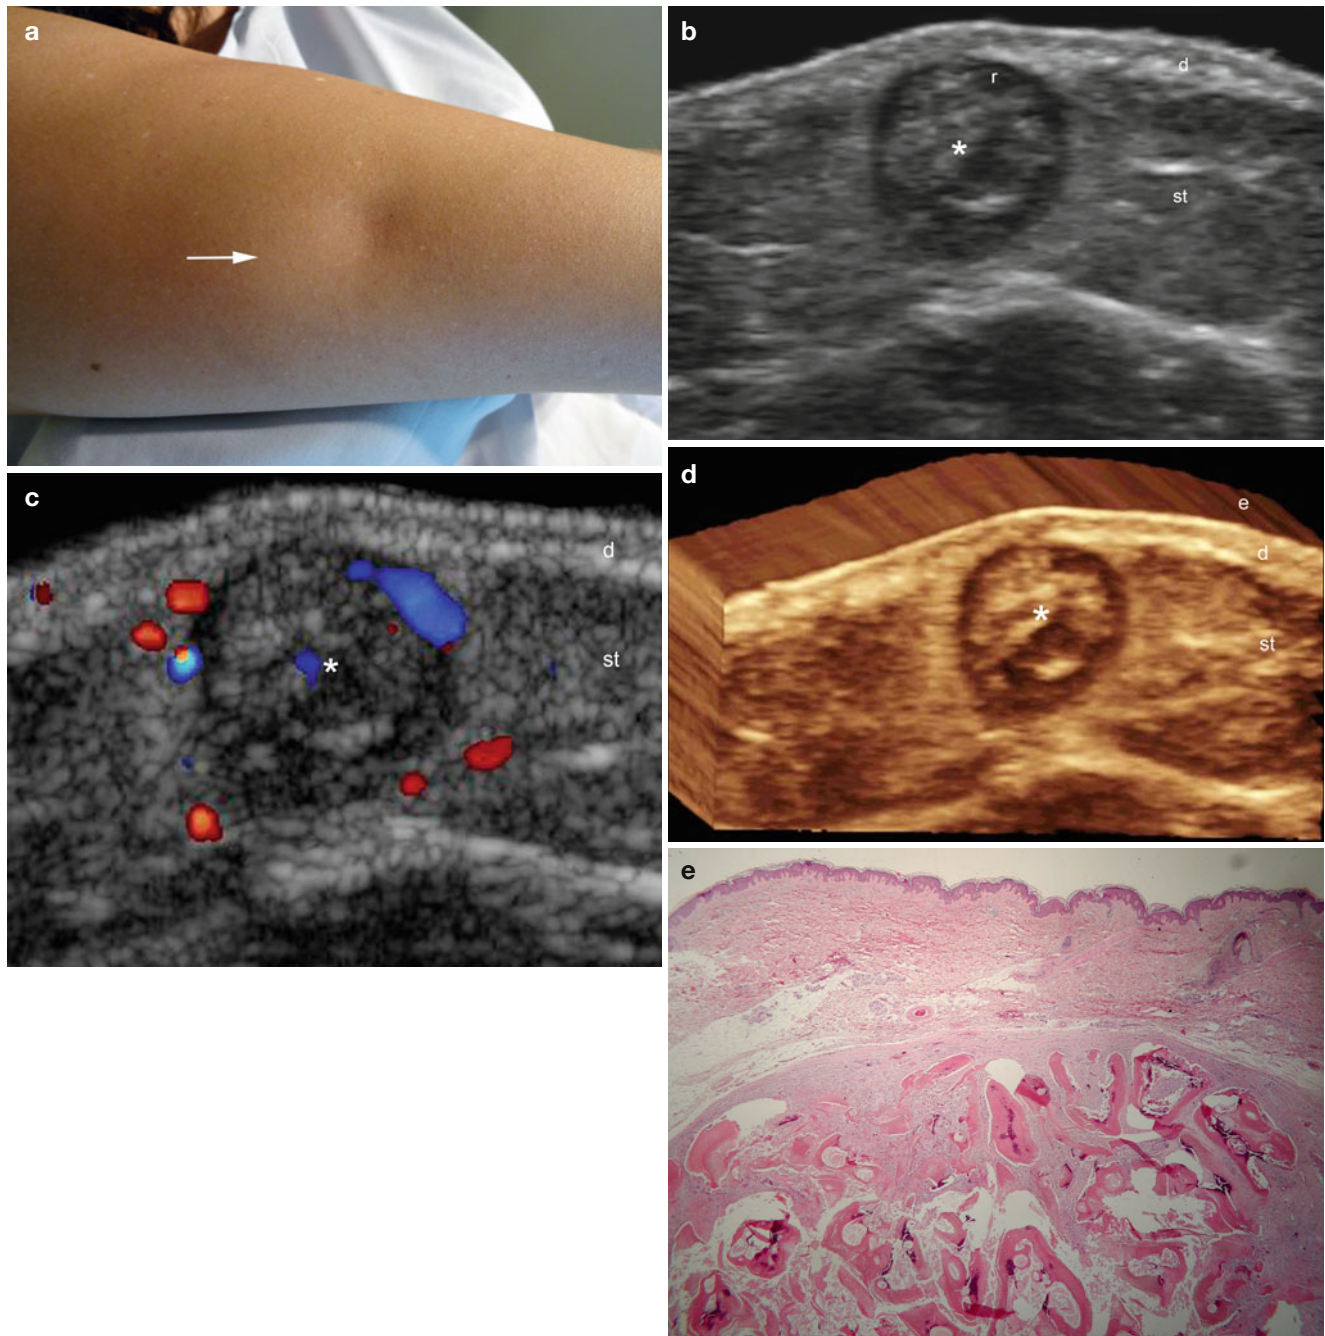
(a–e) Pilomatrixoma. (a) Palpable lump in the dorsal right arm (*arrow*). (b) Grey scale ultrasound image (transverse view) shows a well-defined round-shaped subcutaneous solid nodule that presents a hypoechoic rim (*r*) and hyperechoic center (*, calcium deposits). This is the classic “target appearance” of pilomatrixomas. (c) Color Doppler ultrasound image (transverse view) demonstrates increased vascularity
